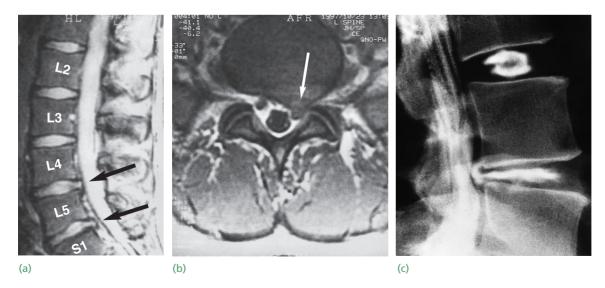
MRI and discography (a) The lateral T2-weighted MRI shows a small posterior disc bulge at L4/5 and a larger protrusion at L5/S1. (b) The axial MRI shows the disc prolapse encroaching on the intervertebral canal and the nerve root on the left side. (c) Discography, showing normal appearance at the upper level and a degenerate disc with prolapse at the level below.
